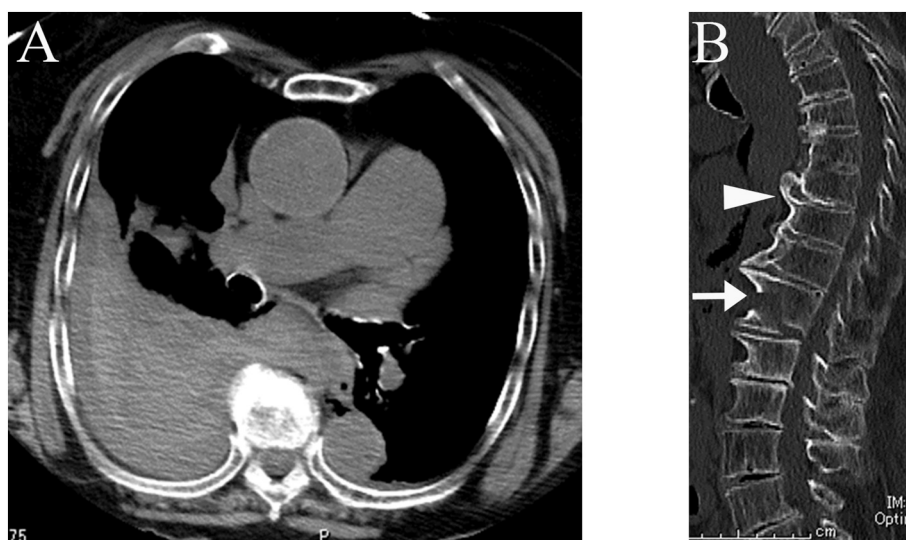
Computed tomography shows a massive right hemothorax in the axial plane (A) and a 12th thoracic (T12) AO-B3 spinal fracture (arrow) and diffuse idiopathic skeletal hyperostosis (arrowhead) in the sagittal plane (B).
